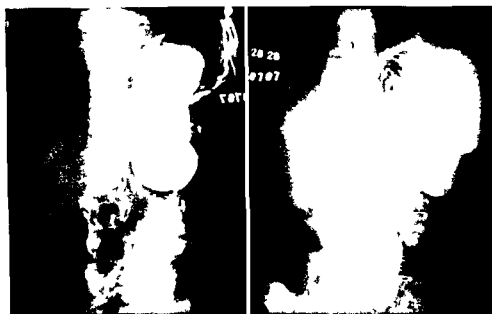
left Roentgenogram of stomach on admission A diaphragmatic hernia is shown with herniation of practically the entire stomach into the left thoracic cavity and extending to the fifth rib posteriorly The opening is close to the oesophageal hiatus
